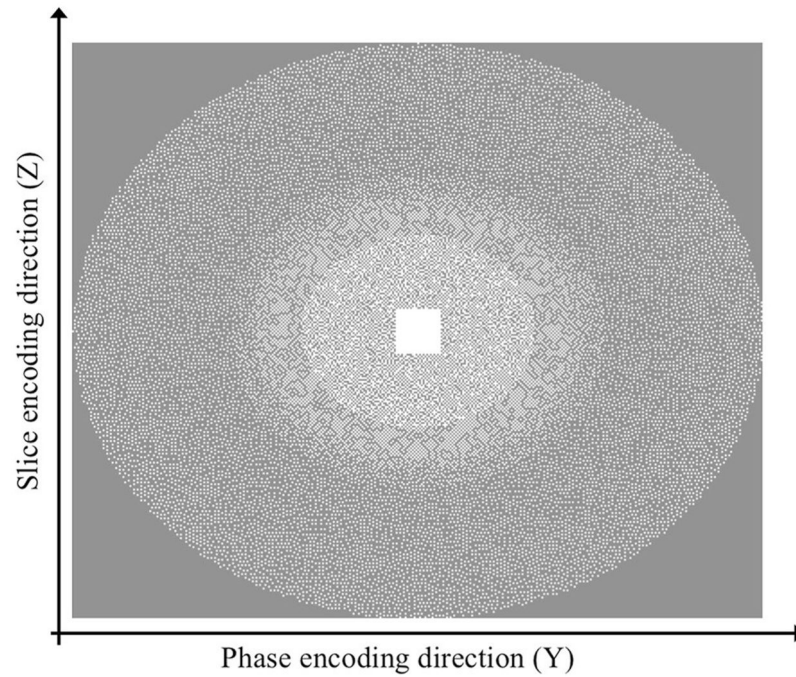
The k -space sampling pattern used in CS-SPACE. A variable density Poisson disc distribution was used in the kz - ky plane in 3D MR imaging with a 24×24 fully sampled region around the k -space center. No undersampling was done along the readout direction
